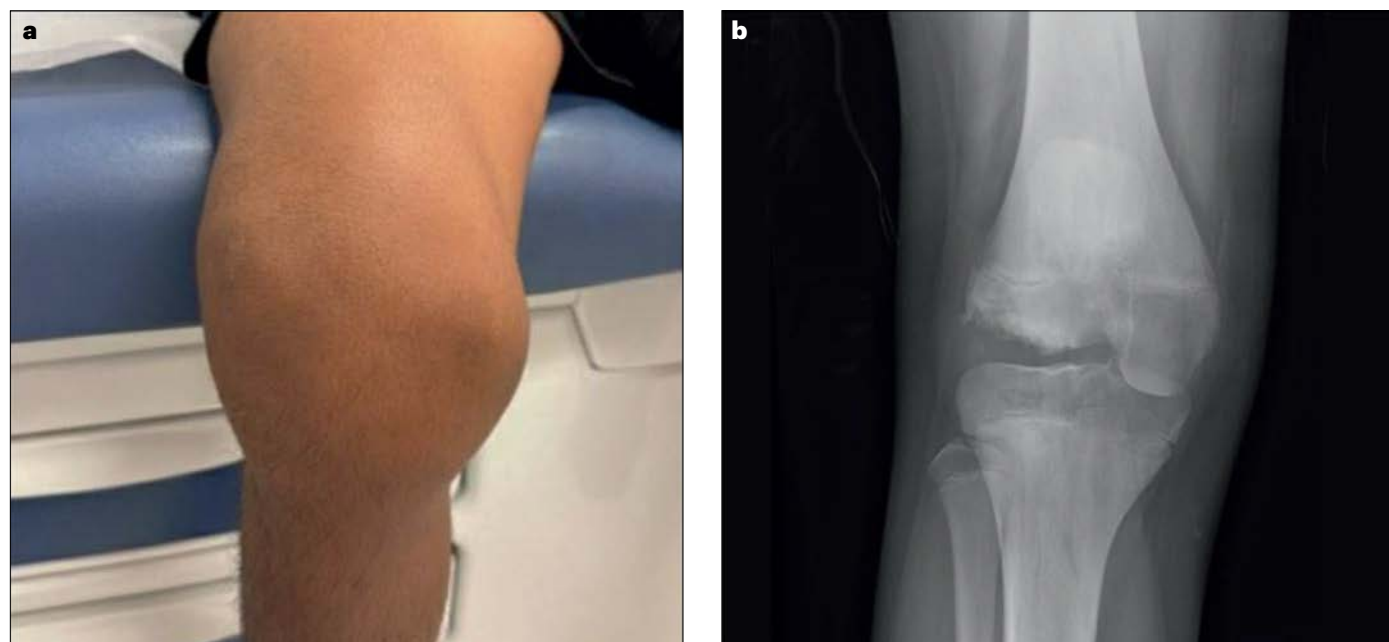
Knee arthrosis in a paediatric patient with α -mannosidosis. a,b, Clinical and radiographic findings in a 17-year-old male patient with α -mannosidosis. Panel a shows the external appearance of the affected knee. Panel b shows
